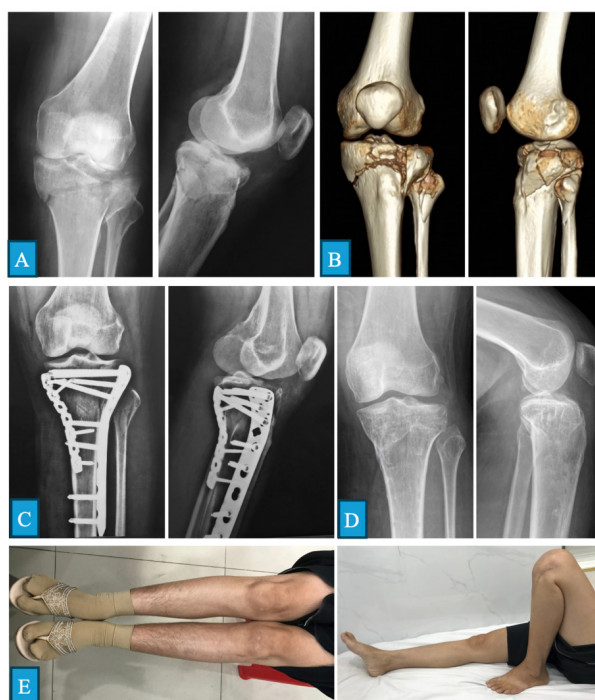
A 41-year-old woman with a S.VI tibial plateau fracture sustained in a motorcycle accident. (A) Initial knee radiographs and (B) 3D CT reconstruction. (C) Postoperative radiographs. (D) Radiographs and (E) clinical photographs at the 5-year follow-up.
